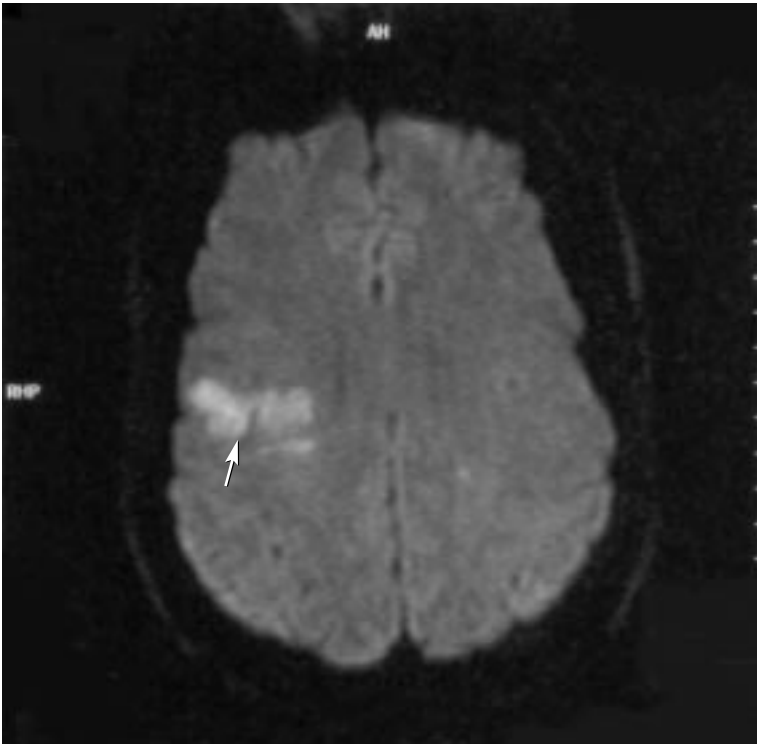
Magnetic resonance image of the brain showing multiple foci of acute infarction involving different vascular territories and suggesting an embolic source. The largest of the infarcted areas is in the caudal aspect of the right precentral gyrus (arrow).
